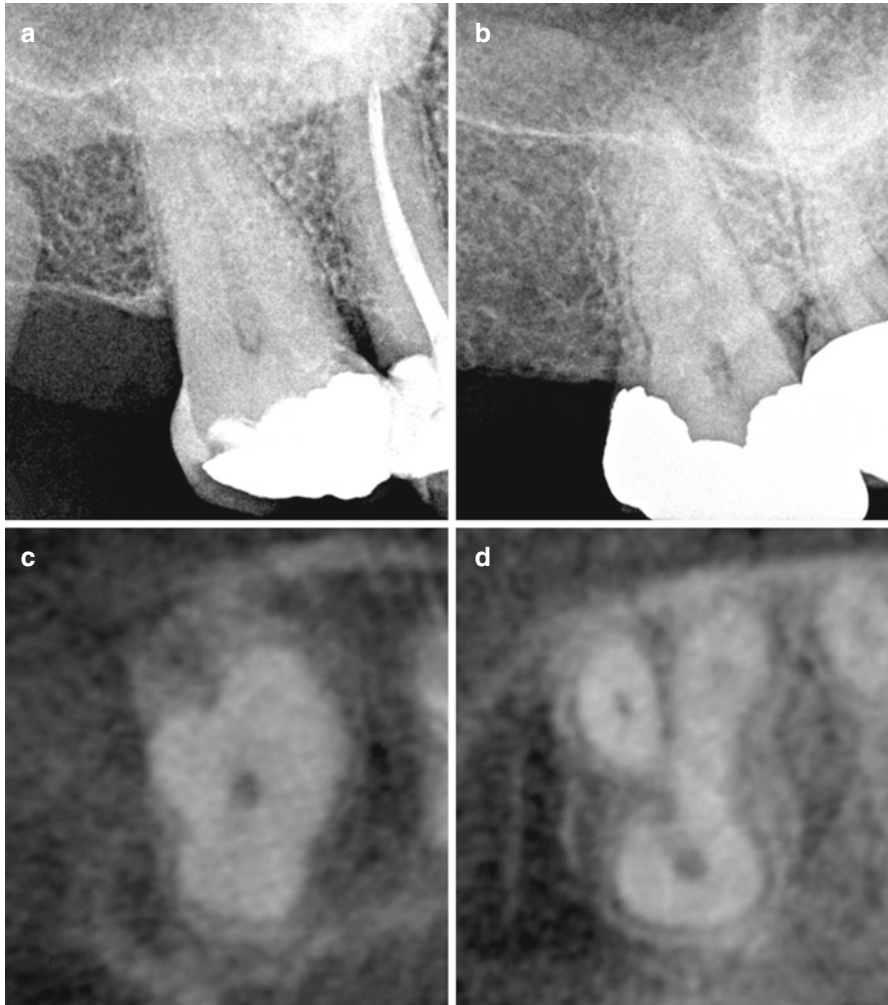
Preoperative periapical radiographs of two different right maxillary second molars with conically shaped roots (a, b) and their corresponding axial CBCT slices (*below*) demonstrating different external root forms and different internal canal configurations (c, d)
